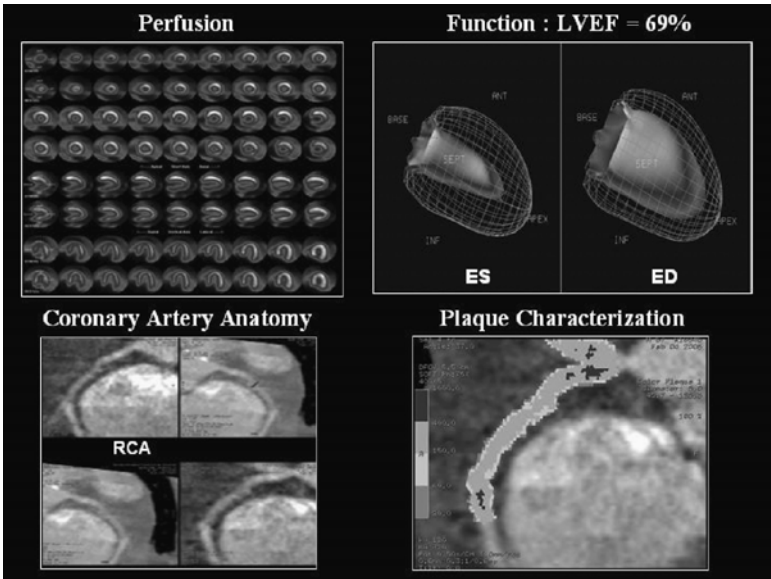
Combined PET/CT scan demonstrates inferior wall ischemia on the myocardial perfusion image. The left ventricular ejection fraction (LVEF) is normal (69%). Atherosclerotic disease is demonstrated in the proximal right coronary artery (RCA), the composition of which can be characterized by analysis of plaque density.
